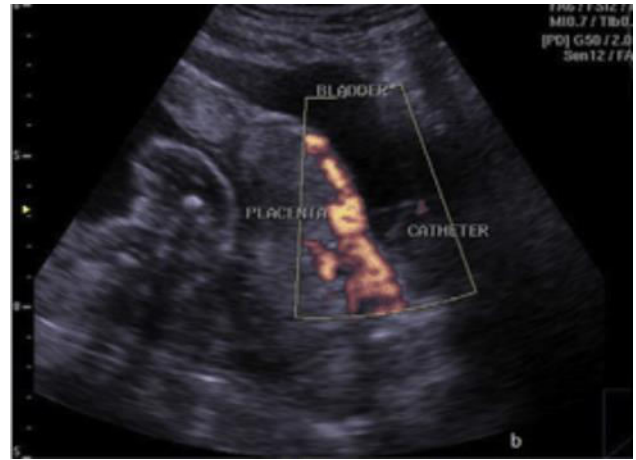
Placenta accreta in 30 year old pregnant female patient at 28 weeks of gestation, was known to have placenta previa during routine antenatal examination with history of previous 5 C.S. Power Doppler shows heterogenous placenta, loss of retroplacental clear space, increased vascularity of the interface & decreased myometrial thickness. Patient was found to have placenta percreta at delivery.
